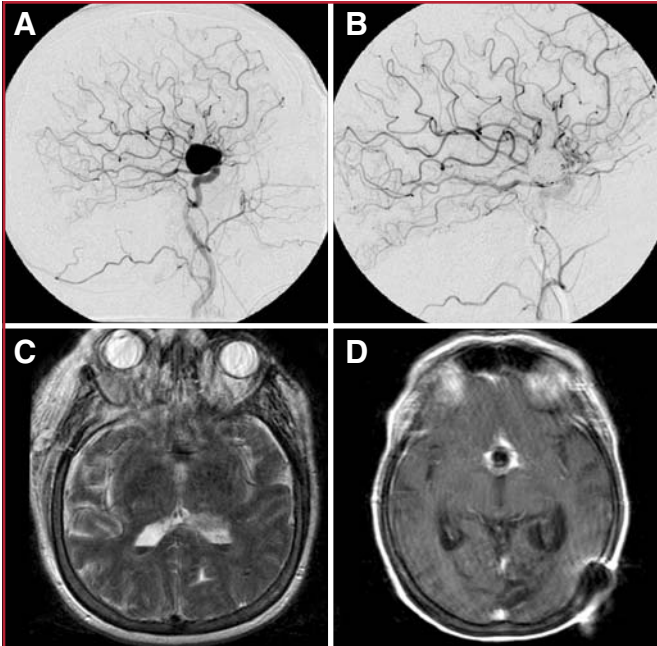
A and B, pre- (A) and postoperative (B) lateral angiograms significant for a coiled large right internal carotid artery aneurysm and a patent ophthalmic artery. C and D, magnetic resonance images. The pre-embolization T2-weighted image (C) shows minimal perianeurysmal edema. After muslin wrapping and coil embolization, the postgadolinium T1-weighted image (D) shows enhancement surrounding the hypointense coil mass.
